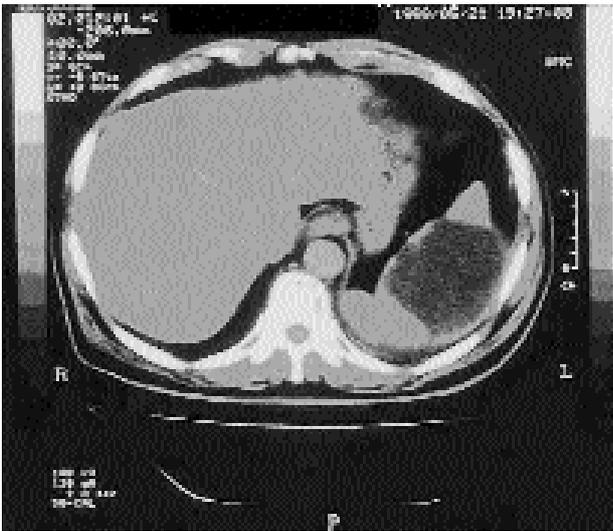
CT shows splenic subcapsular haematoma.
